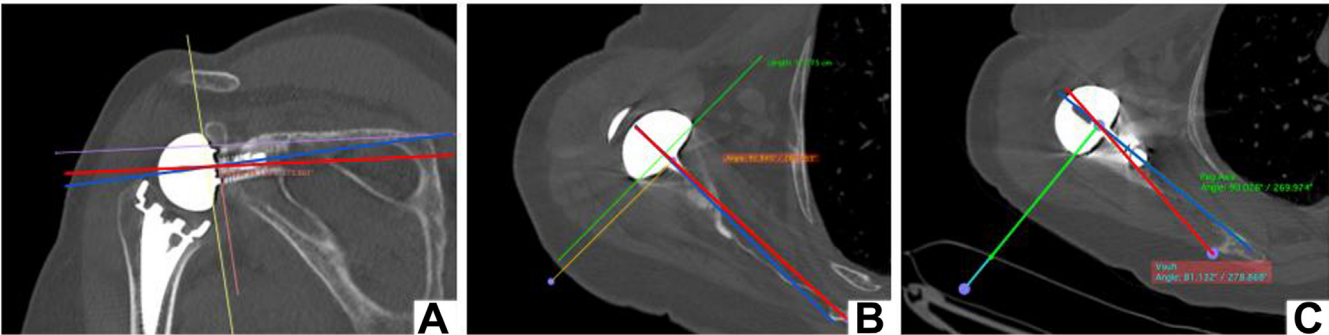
Postoperative computed tomography (CT) scan measurements. (A): CT scan coronal slice showing RSA angle measurement (—: RSA line/—: peg's axis). (B): CT scan axial view representing the measurement of the Friedman angle (—: Friedman line/—: peg's axis). (C): CT scan axial view with the glenoid vault angle measurement (—: vault line/—: peg's axis). RSA, reverse total shoulder arthroplasty.
